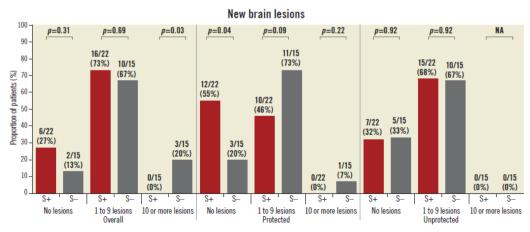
Occurrence and distribution of brain lesions by MRI.
